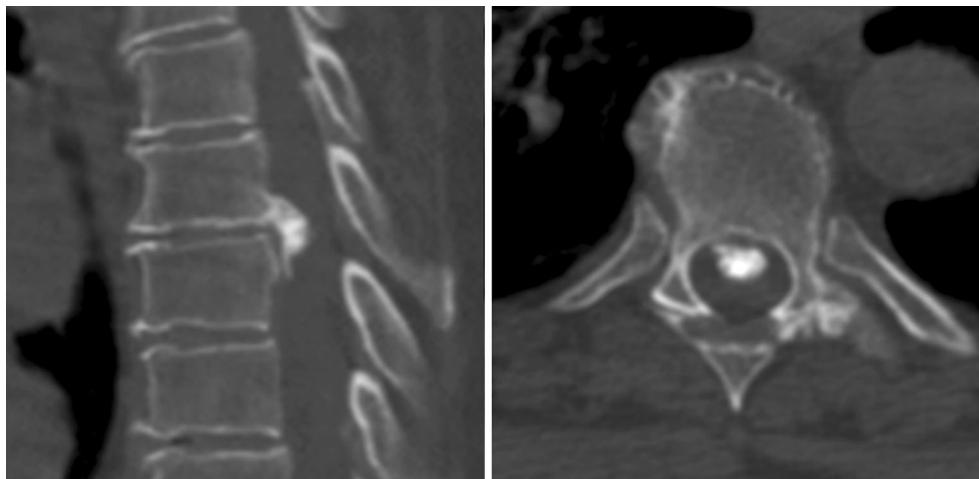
Case 2 CT scan showing the herniation as centrally located and densely calcified (CCDH)
